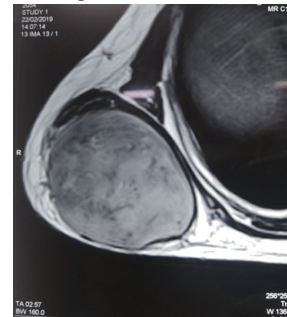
MRI of the swelling
